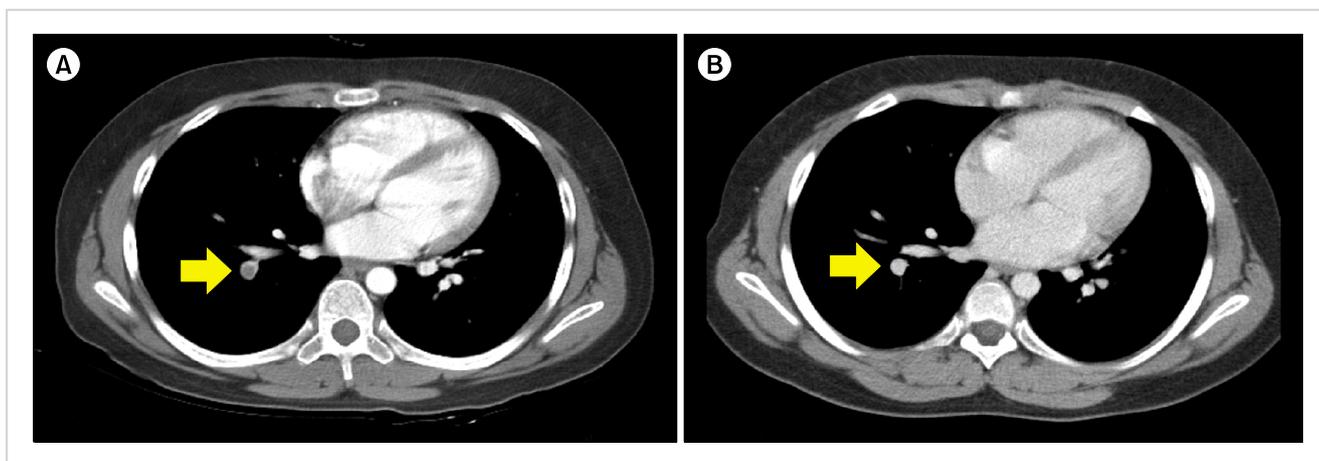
Chest computed tomography showing a pulmonary thromboembolism in the main, lateral, and posterior basal segmental pulmonary artery on the right lower lobe (A, arrow). The thromboembolism resolved after 2 weeks of heparin and warfarin therapy (B, arrow).
